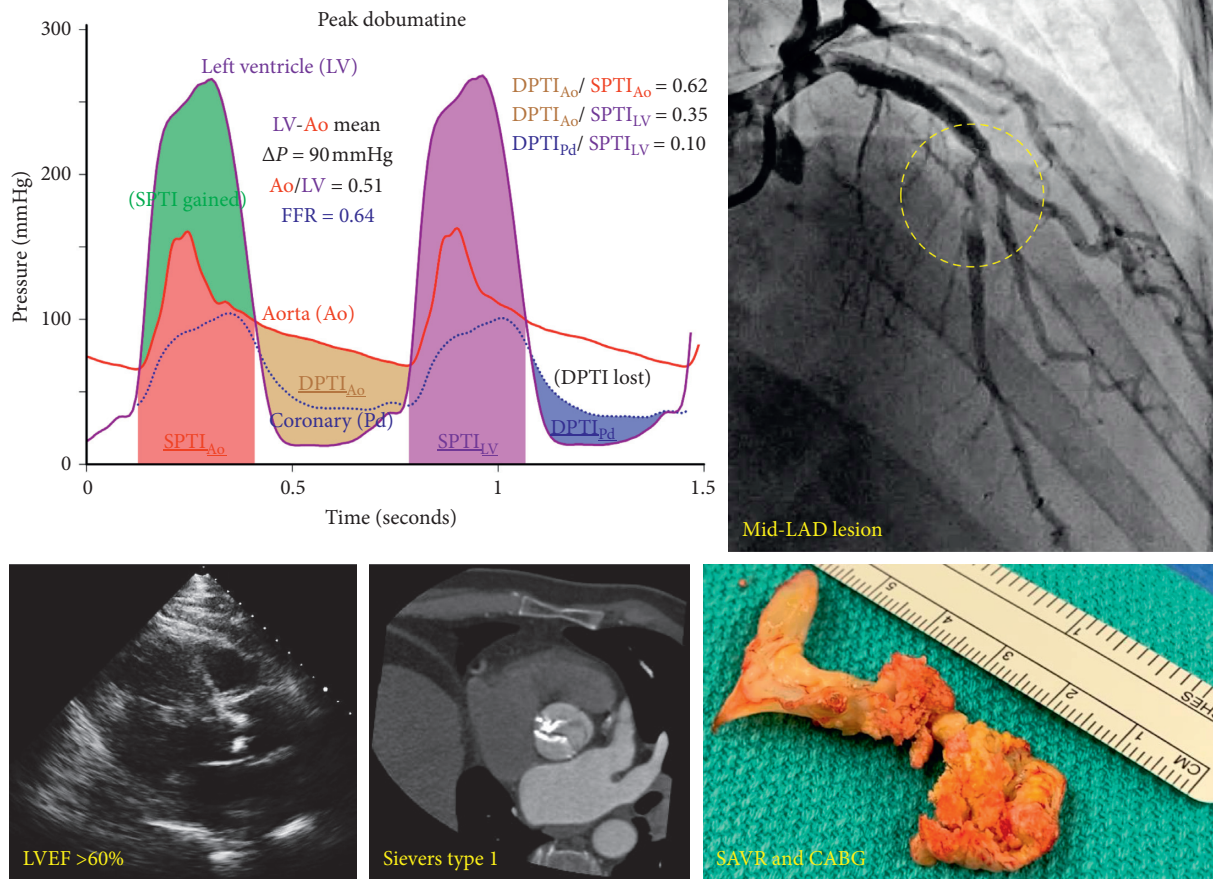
Clinical case of asymptomatic but severe stenosis: as detailed in the text, this 55-year-old asymptomatic man was referred for an incidental heart murmur on routine physical examination. A treadmill exercise test showed good functional capacity with no symptoms or abnormal responses, and echocardiography found normal ejection fraction. However, his bicuspid aortic valve had moderate-to-severe stenosis at baseline, rising to a mean gradient of 90 mmHg during intravenous dobutamine stress. Furthermore, his left anterior descending (LAD) coronary artery had an angiographically moderate-to-severe stenosis and fractional flow reserve (FFR) of 0.64 during intravenous adenosine infusion. When superimposing these curves (the distal coronary pressure tracing has been time-scaled to match the aortic pressure tracing), myocardial oxygen demand (systolic pressure time integral, or SPTI) greatly exceeds diastolic coronary supply (diastolic pressure time integral, or DPTI) due to increased SPTI from aortic stenosis and decreased DPTI due to coronary stenosis. Despite normal left ventricular function and a lack of symptoms, the patient underwent surgical aortic valve replacement (SAVR) and concomitant coronary artery bypass grafting (CABG) for extremely abnormal hemodynamics.
